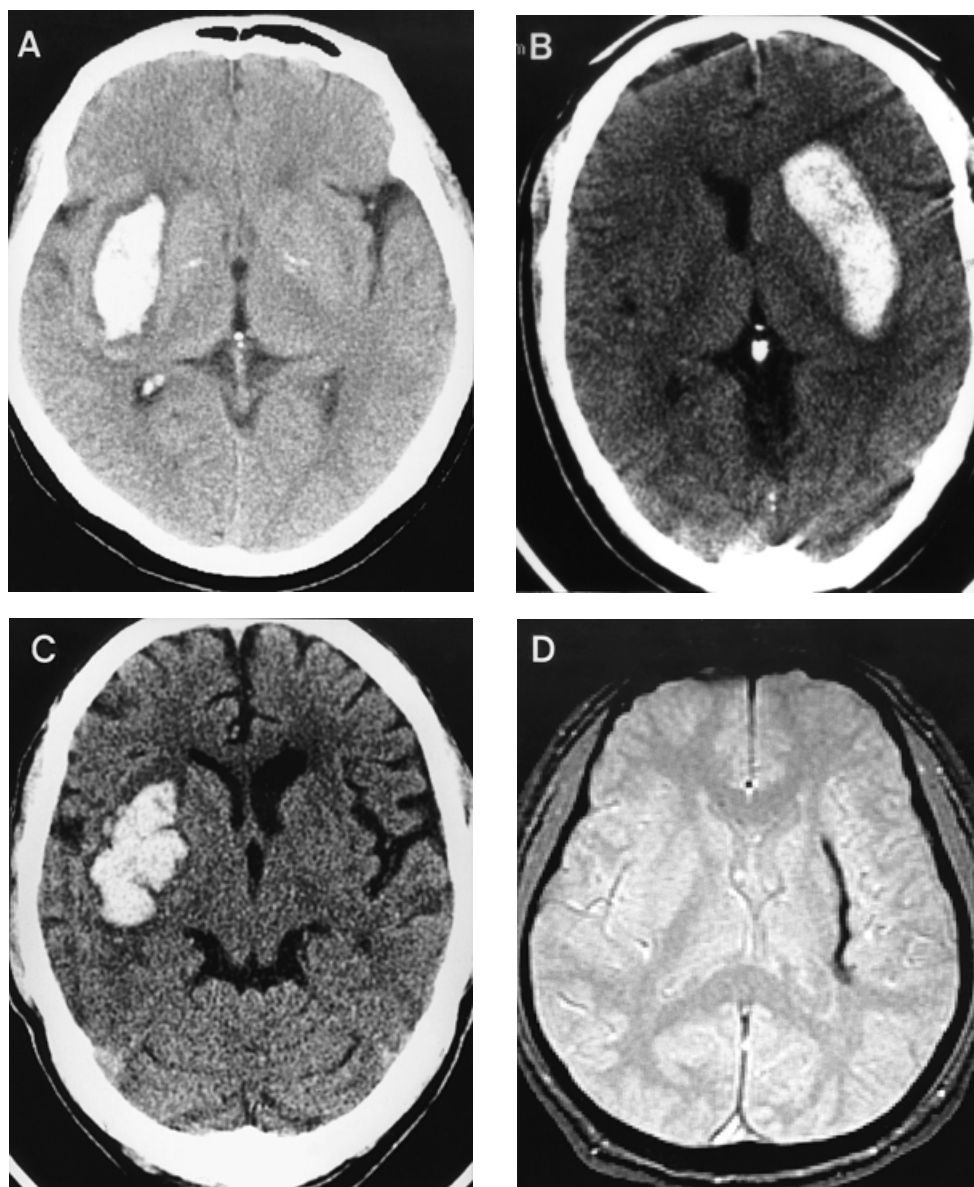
CT (A–C) and MR (D) images showing the lateral type of SCHs. As shown in A–C, they are usually located between the insular cortex and the putamen, forming long elliptical haematomas that exert pressure on the lateral part of the putamen. They usually leave a slit-like low signal lesion on the follow-up gradient echo MR image (D and 3 months after the onset in the patient in C).
